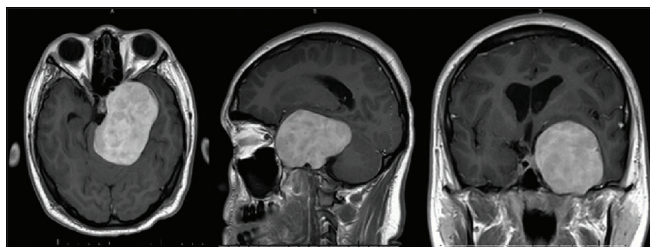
Preoperative magnetic resonance imaging figure description: contrasted T1-weighted magnetic resonance imaging with axial, sagittal, and coronal views of the 5.2 × 7.8 × 5.1 cm heterogeneously extra-axial enhancing mass centered in the left mesial temporal region with involvement of the skull base and left foramen ovale, rotundum and spinosum, encasement and moderate narrowing of the left internal carotid artery, mild obstructive hydrocephalus, and marked compression of the brainstem.
